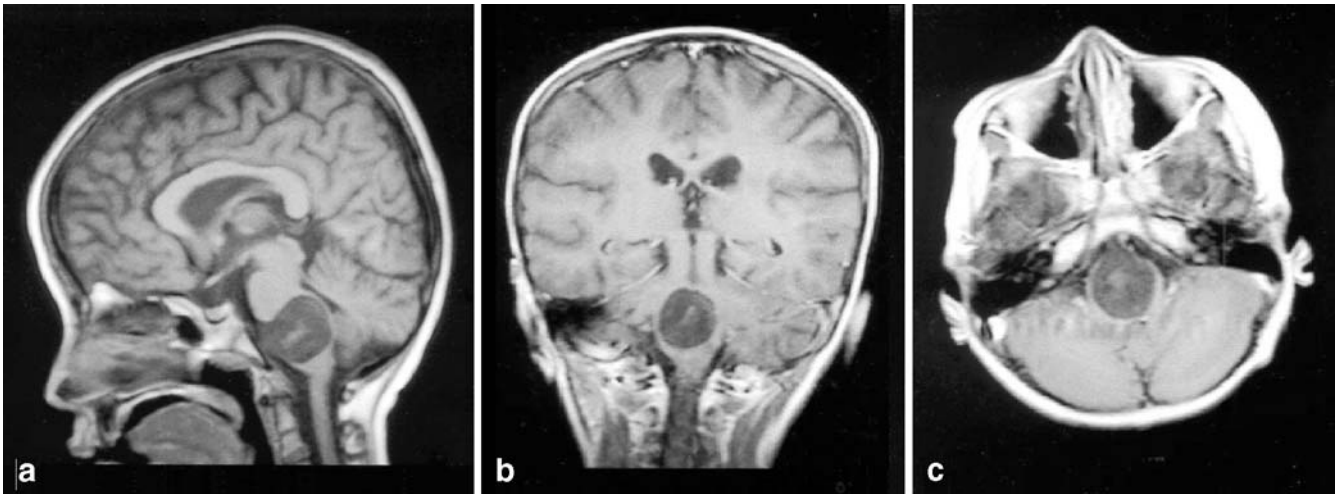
Preoperative sagittal (a), coronal (b) and axial (c) MRI scans of a 5-year-old female demonstrated a round mass lesion in medulla oblongata. Perioperatively, shortly after midline medullectomy, a white-milky fluid drained from the lesion cavity. There was also some ordinary epidermoid cyst content in the center of the lesion cavity which can also be recognized on the preoperative MRI scans
